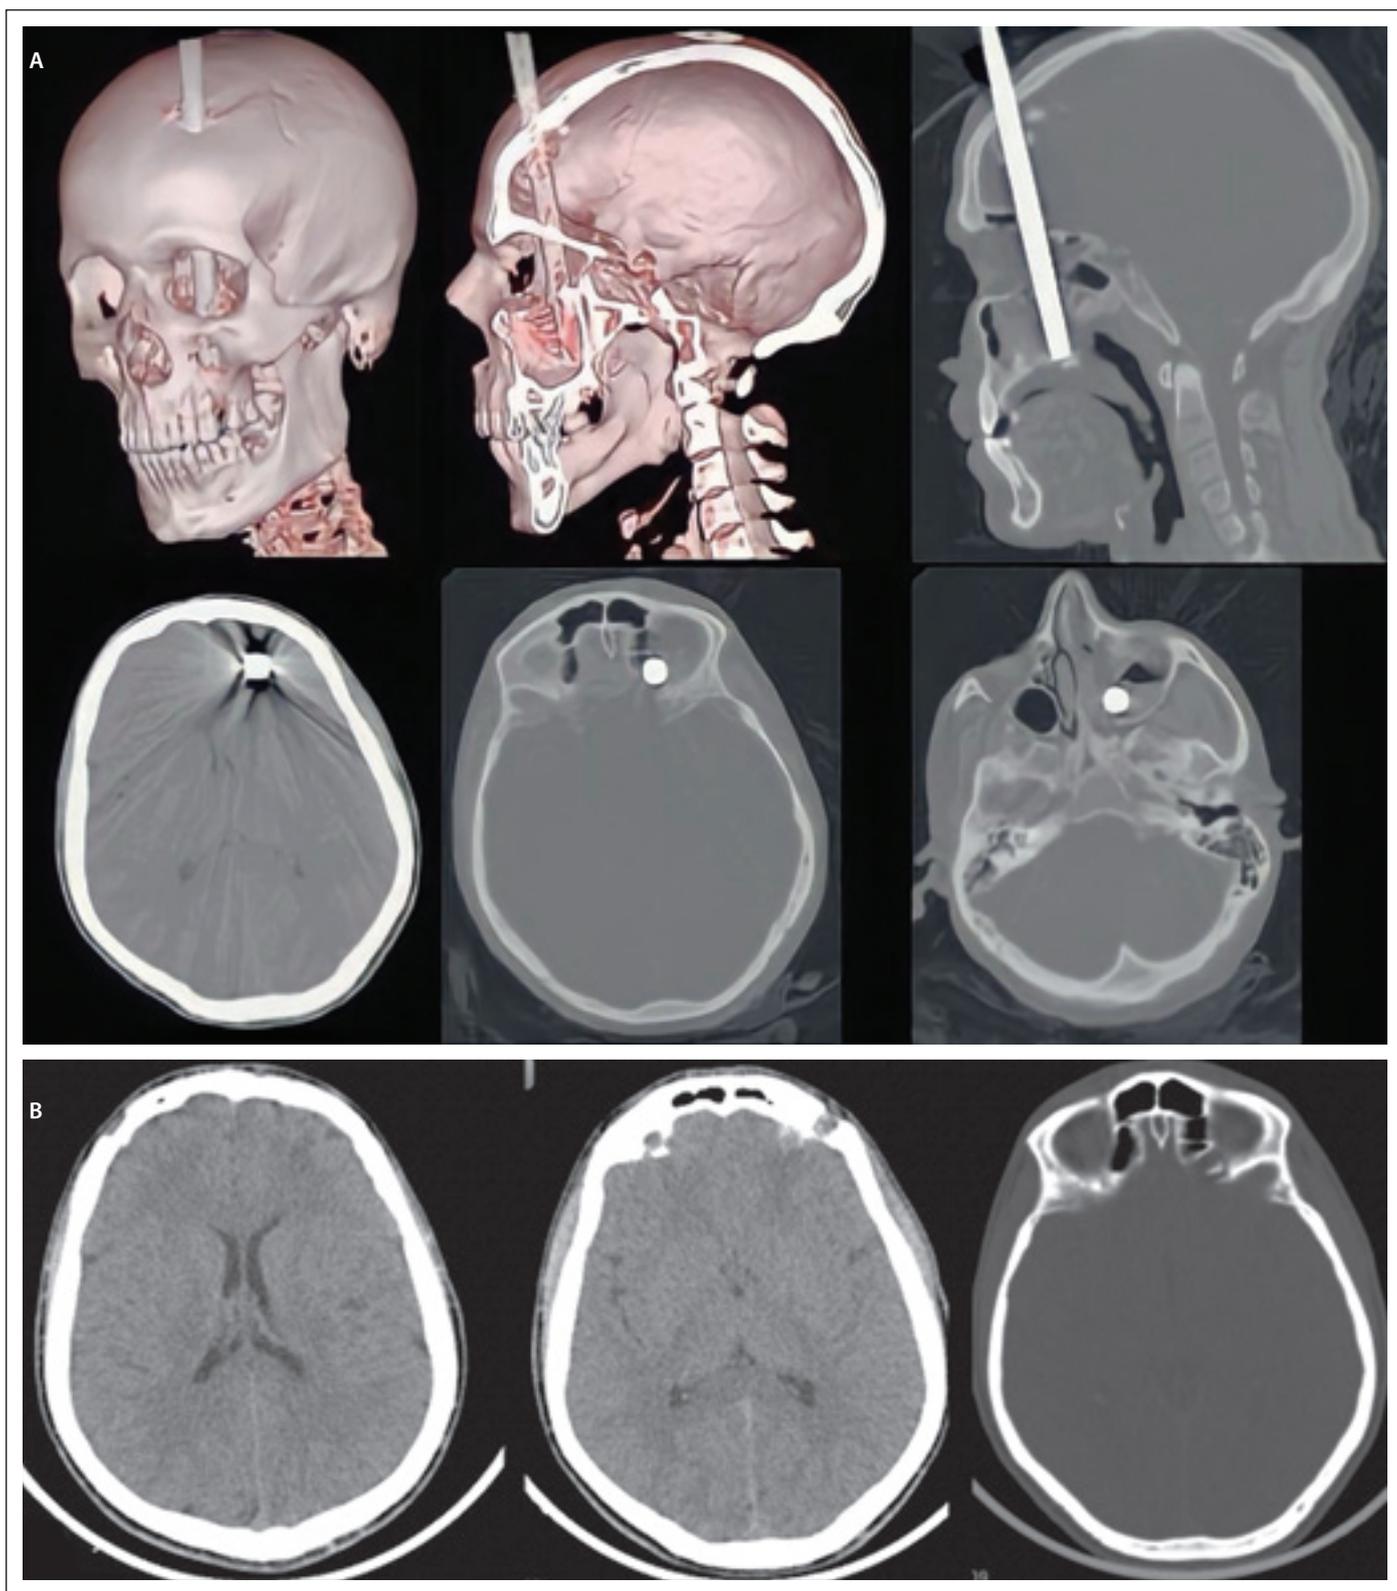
(A) Preoperative brain CT; (B) postoperative brain CT.
